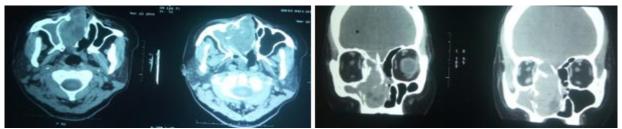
Axial and coronal CT showing tumour occupying the right nasal cavity causing erosion of the nasal septum and medial wall of the maxillary antrum with extension into the maxillary and ethmoidal sinuses.
